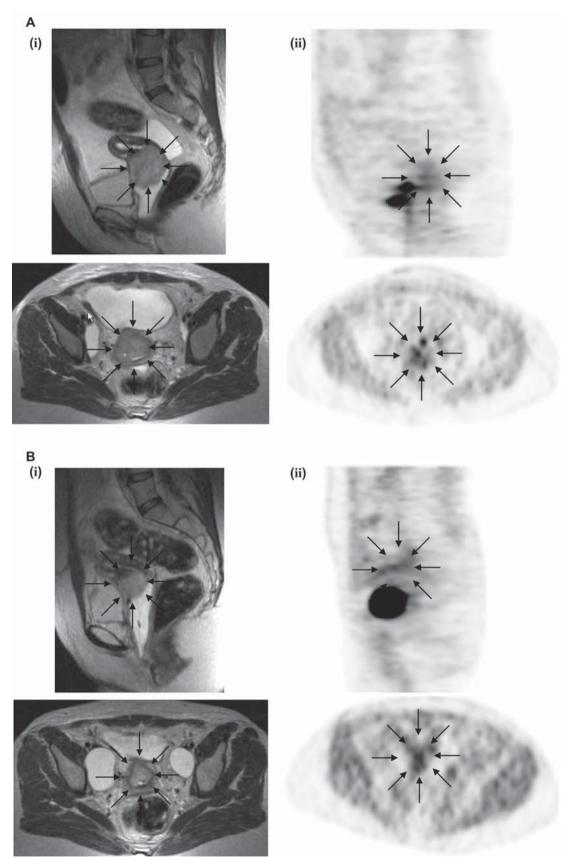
Sagittal and axial MRI (i) and sagittal and axial ¹⁸FAZA PET (ii) imaging in a patient with cervical cancer FIGO stage IIb before therapy (A) and during RT (B) (patient number 6). Arrows indicate the tumor on the MRI (i) and the hypoxic areas within the tumor (ii).
